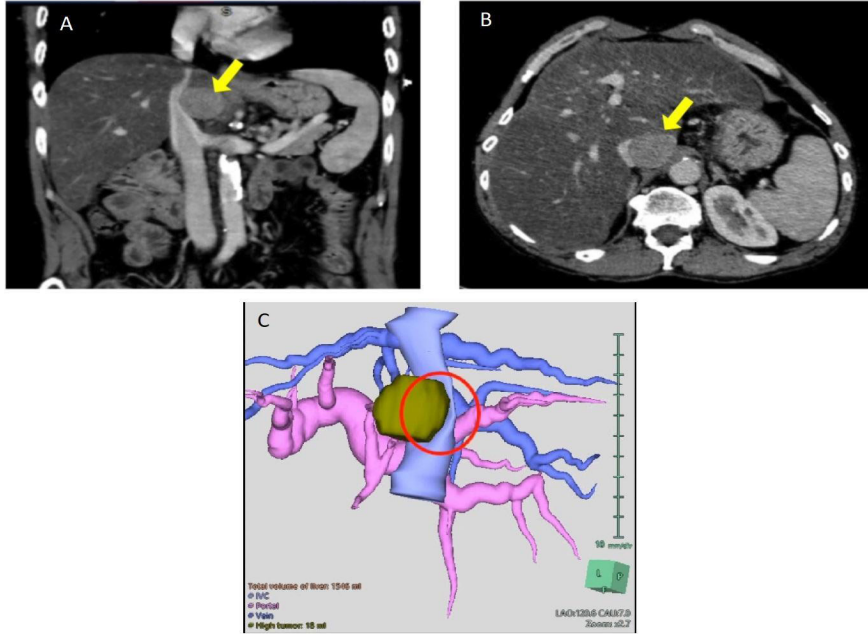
Preoperative imaging of caudate mass showing proximity to and compression of IVC: A) Coronal CT, mass shown with yellow arrow, B) Axial CT, mass shown with yellow arrow, C) 3D reconstruction, mass in dark yellow, IVC and hepatic veins in blue, portal vein and branches in pink
